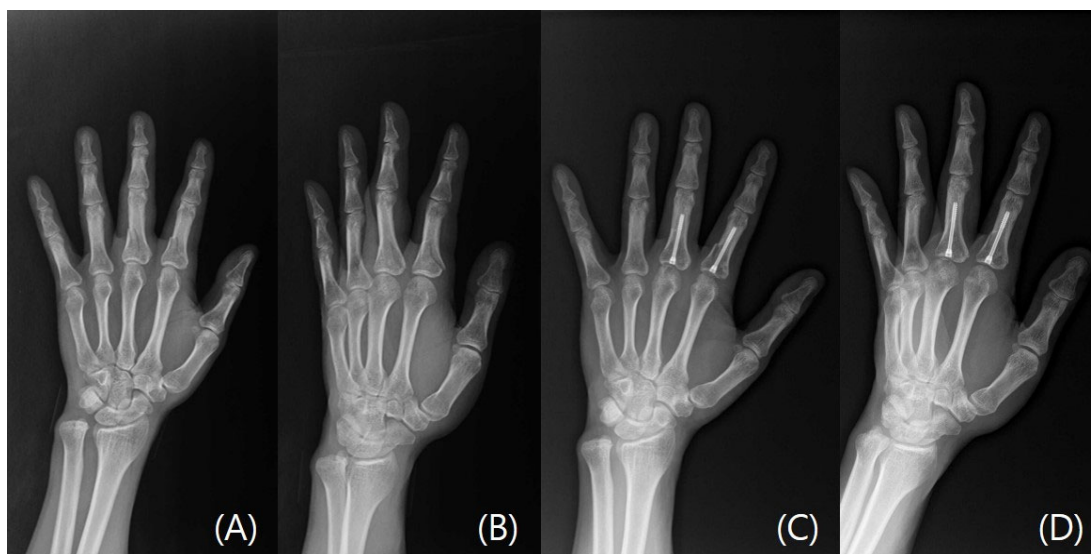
A case of a left second and third digit transverse proximal phalanx fracture. (a) Preoperative plain radiograph PA view; (b) Preoperative plain radiograph oblique view; (c) Postoperative plain radiograph PA view taken at last follow-up visit; (d) Postoperative plain radiograph oblique view taken at last follow-up visit.
